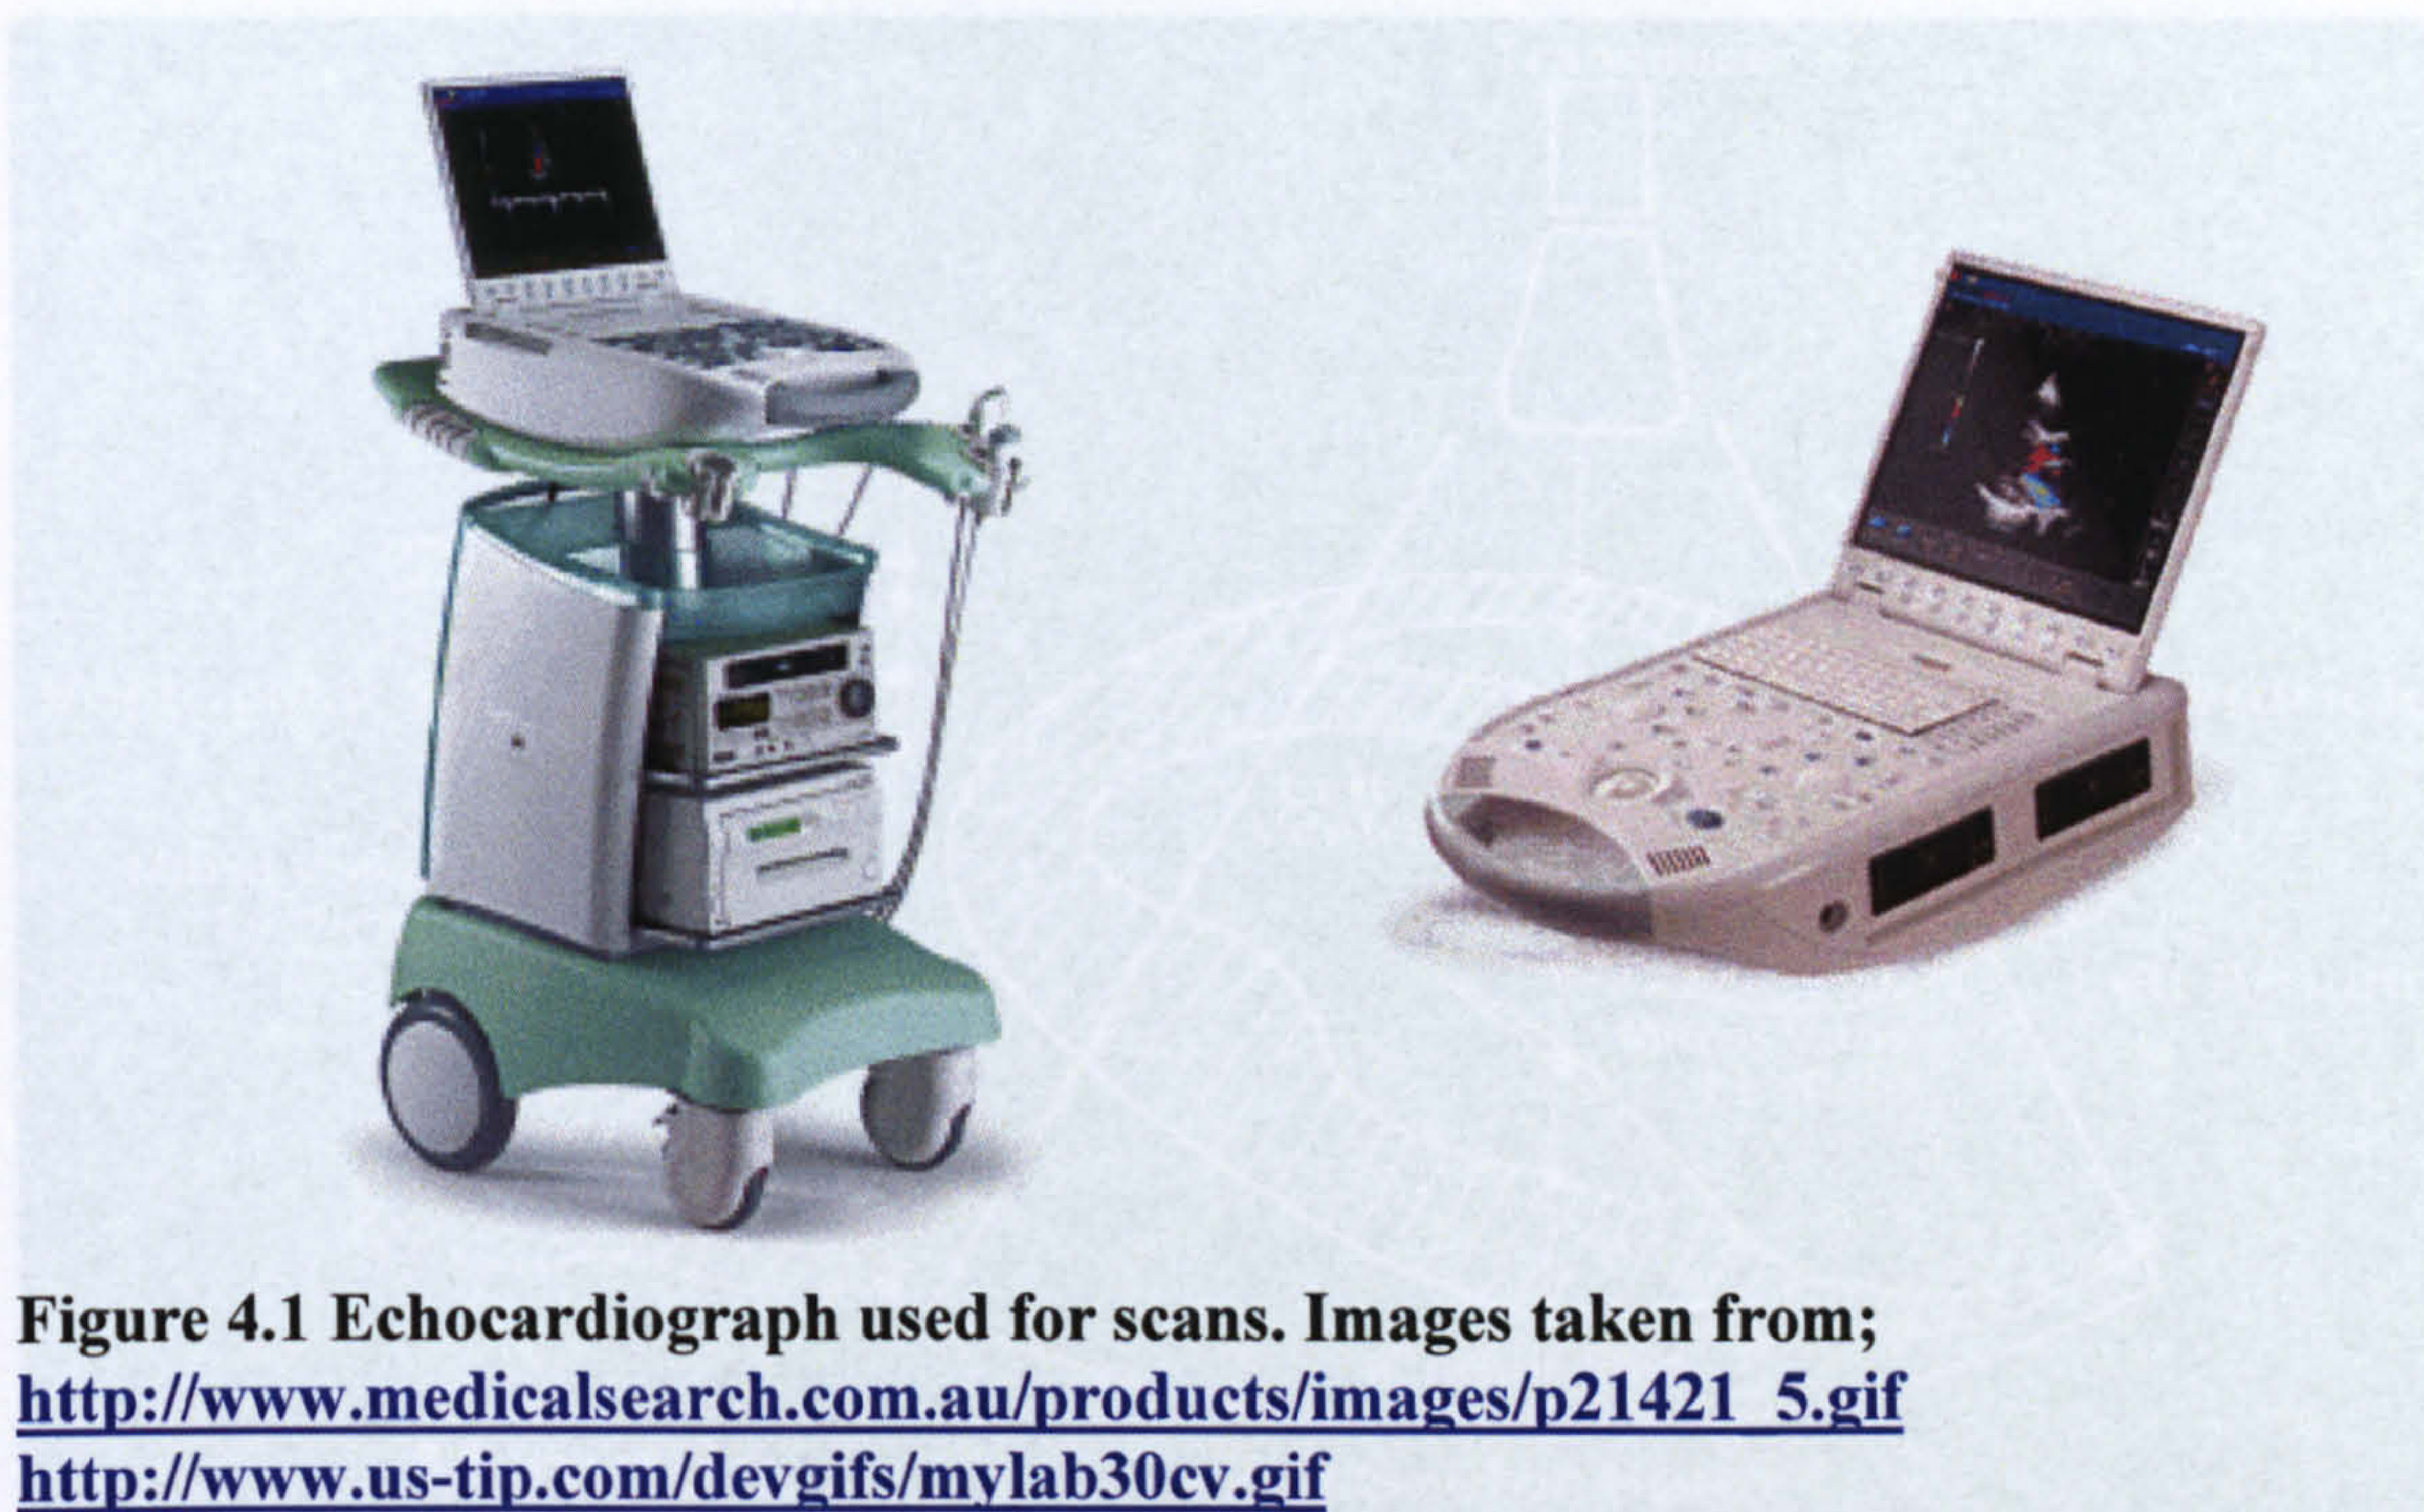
Echocardiograph used for scans. Images taken from;
